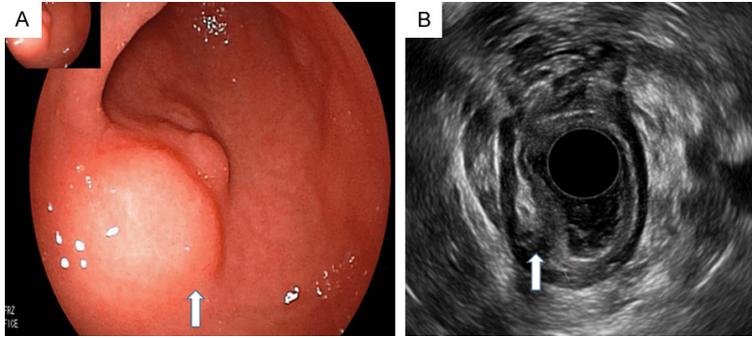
Gastric adenomyoma of Gastroscopy and Ultrasound Endoscopy. A. Gastroscopy showing a mass in the gastric antrum; B. Ultrasound Endoscopy showing the mass originating from the submucosa layer of stomach.
